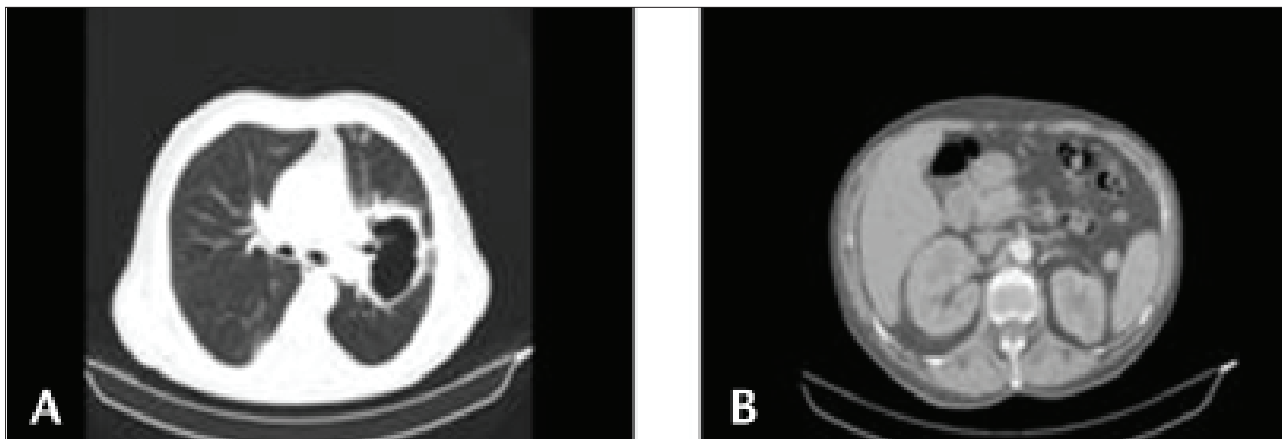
Computed tomography image, (A) renal mass, (B) lung mass.
